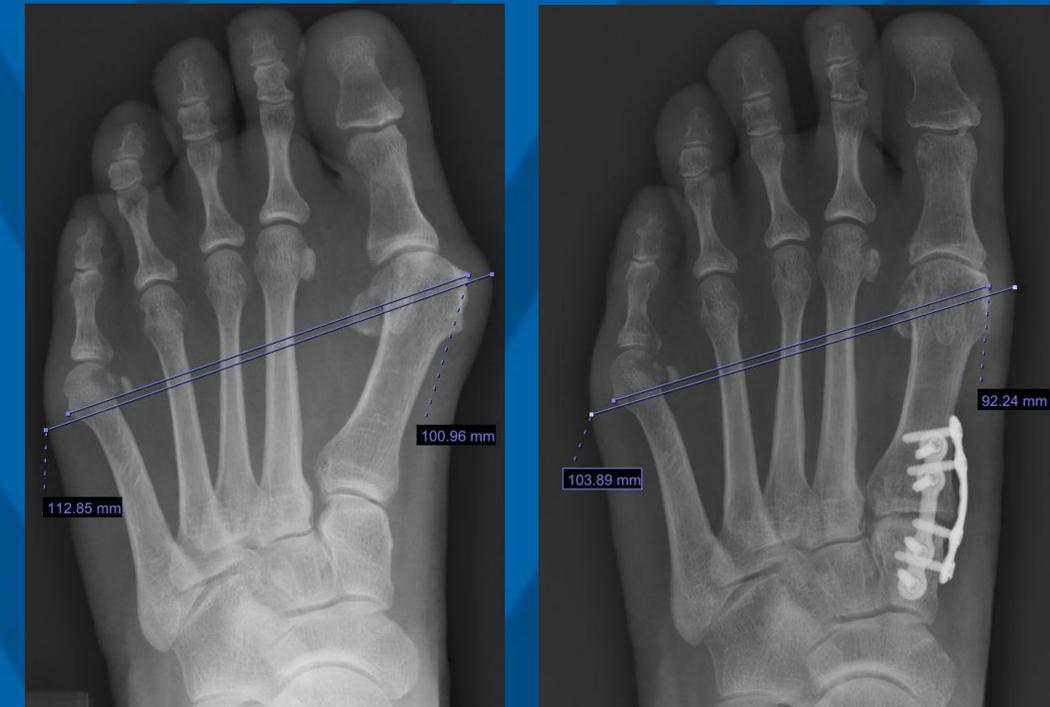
pre- and postoperative AP weight-bearing radiographs
